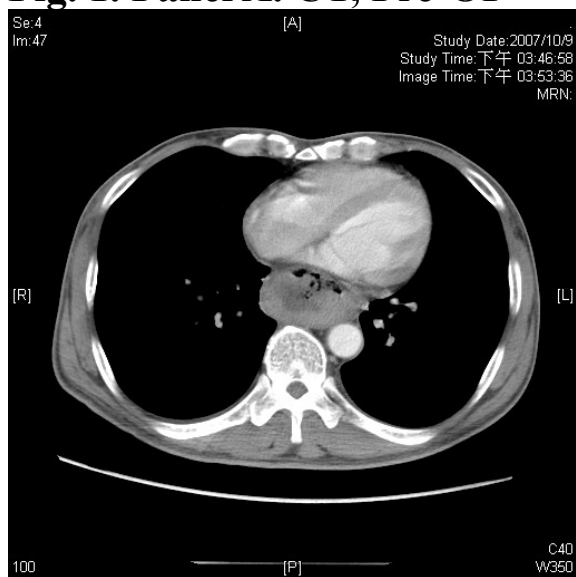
Panel B. CT, Pre-OP
